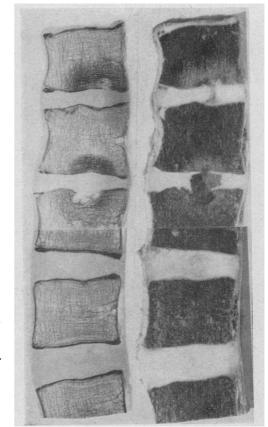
Sagittal section lumbar vertebrae 1-5, showing granulation tissue and breaching of cartilage end-plate with narrowing of discs. X-ray of slice on left and gross photograph on right.
